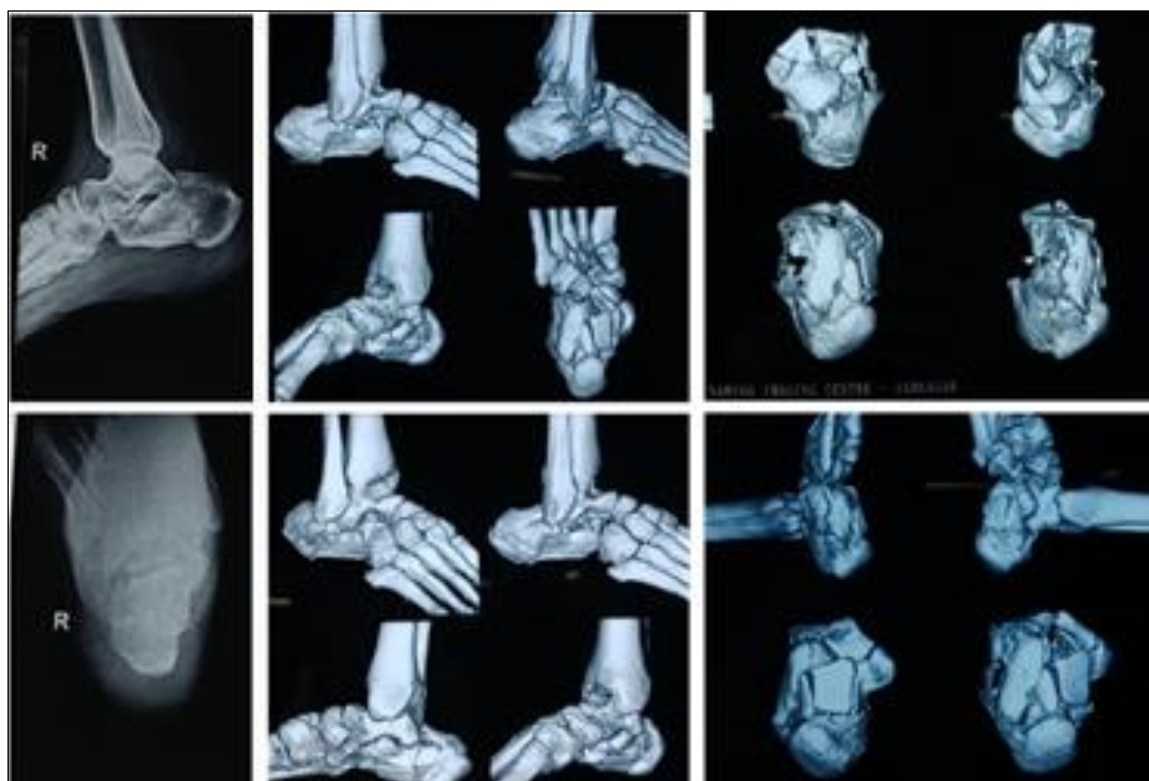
Pre Operative X-Rays and CTscan of Calcaneum
